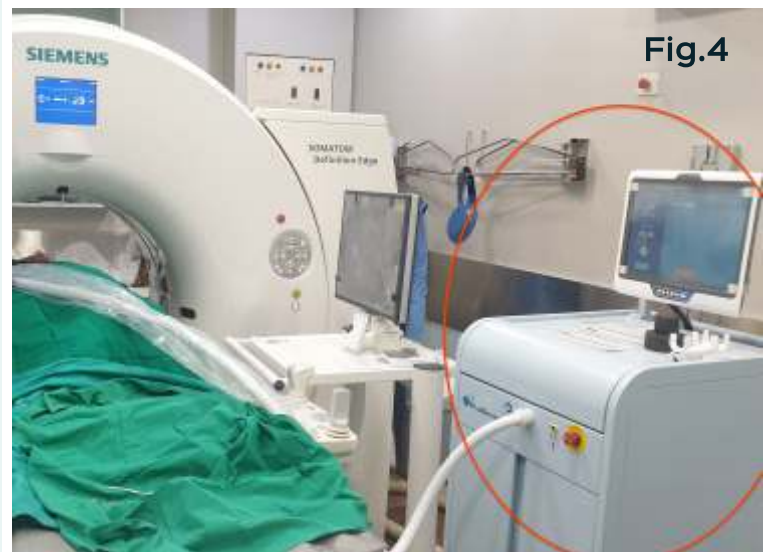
The compact (red circle) cryoablation machine (IceCure, Israel) in the CT scan room at the time cryoablation.
